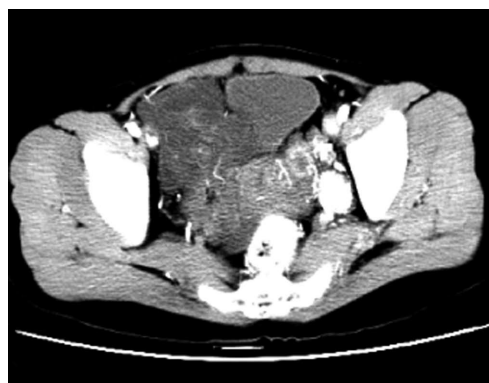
Preoperative pelvic contrast enhanced computed tomography shows a big irregular mass exhibiting heterogeneous enhancement.
